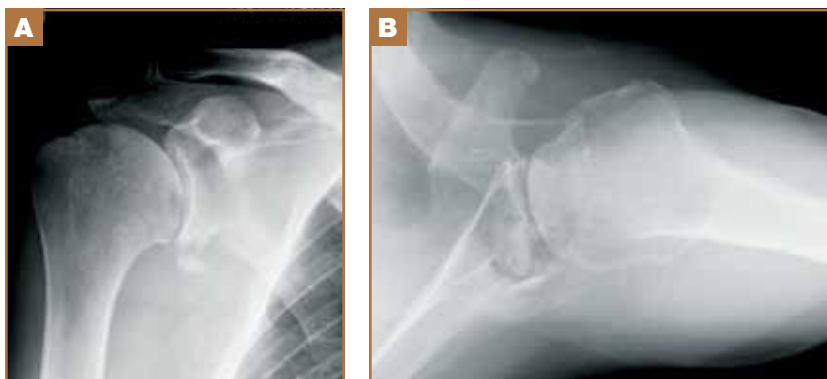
Preoperative radiographic images in AP (A) and axillary view (B) showing non-concentric glenohumeral joint alignment with static posterior subluxation. Marked irregularity of the posterior aspect of the glenoid with joint depression and bone loss are also evident.
